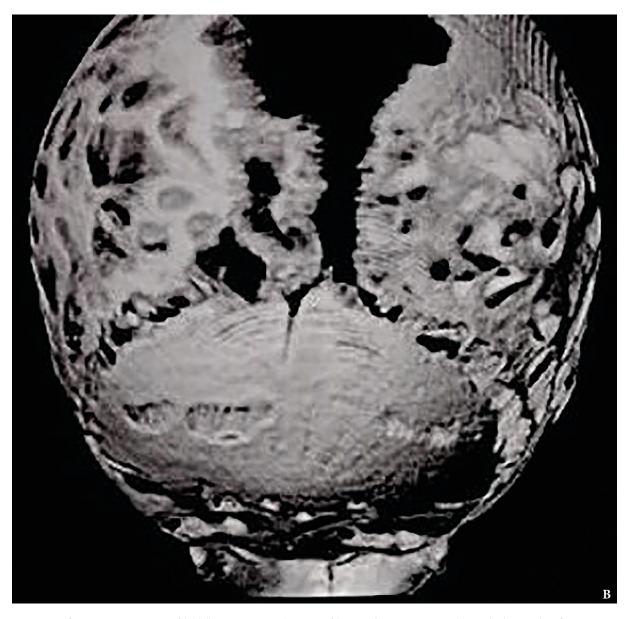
(cont'd). 3D reconstruction CT scans of the skull: posterior view (B). The increase of the space of metopic suture (asterisk) is noted. (Fig 2 continued on next page.)
